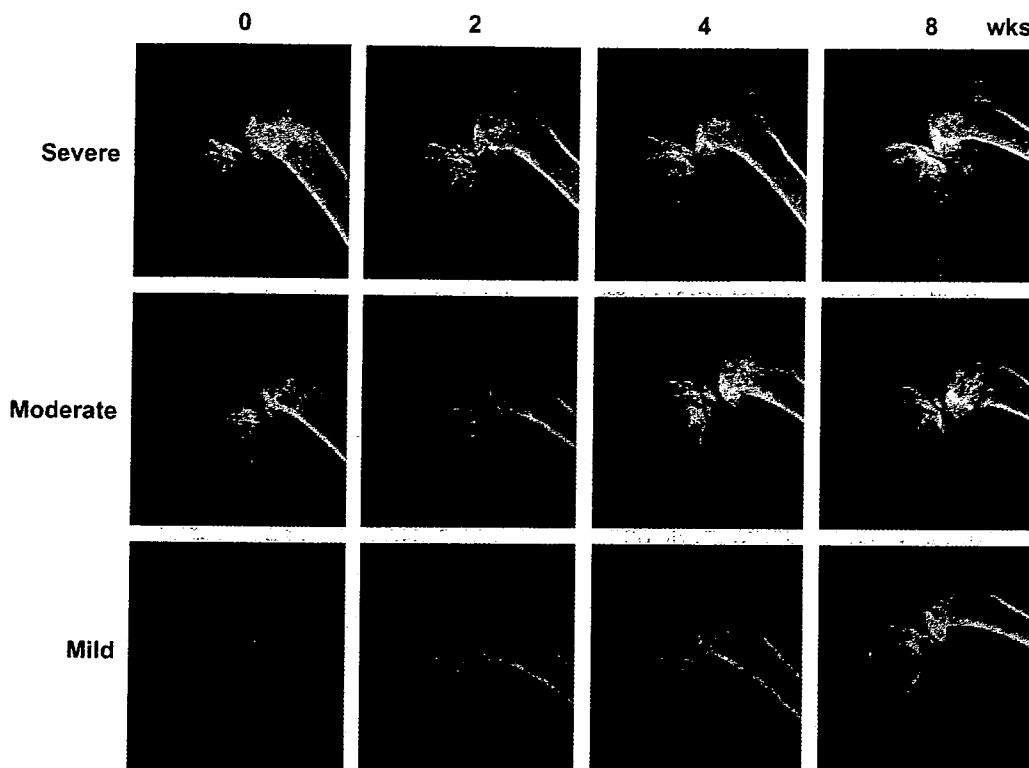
Time course of lateral X-ray features of the knee joints in the severe, moderate and mild models. Radiographs were taken at the indicated weeks after surgery under general anesthesia using a soft X-ray apparatus. Due to the anterior subluxation of the tibiae, joint destruction and osteophyte formation were visible in the posterior tibial plateau. The changes were dependent on the time after surgery and the severity of joint instability.
